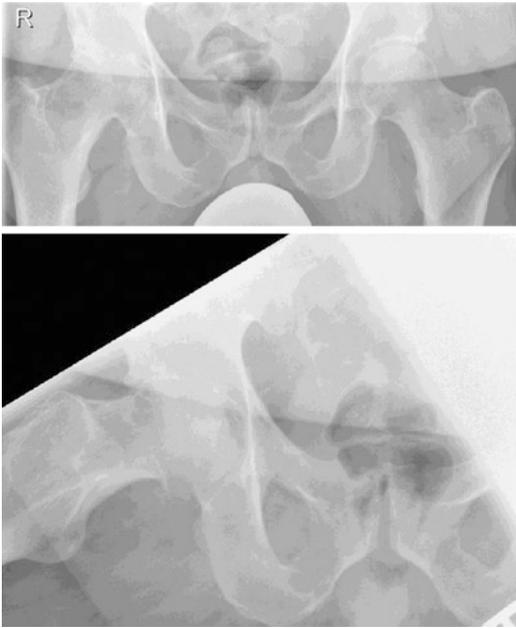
x-ray pelvic ap and Lauenstein view right at the first time of admission
